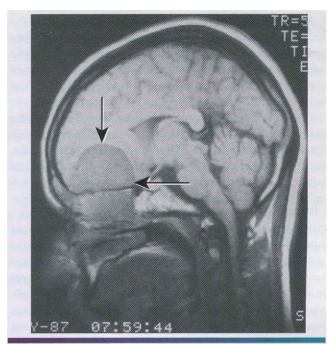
Olfactory neuroblastoma. A TI-weighted sagittal magnetic resonance image (MRI) showing a tumor filling the superior nasal cavity and ethmoid sinus, with extension into the anterior cranial fossa (arrows). (Courtesy of Dr. Pamela Van Tassel.)
